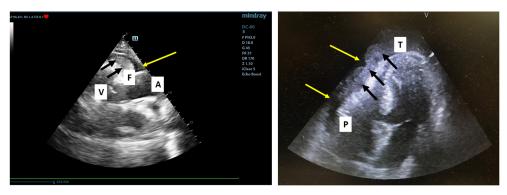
a.3. Left: a case with small quantity of pericardial fluid (transonic, yellow arrow) and intrapericardial fibrin (isoechoic homogenous structure, black arrows); F=fibrin, A=aorta, V=right ventricle (2D, parasternal long axis); Right: a case with cardiac tamponade with medium amount of pleural fluid (transonic structure, yellow arrows) and a big thrombus inside and RV collapse; T=thrombus, P=pericardium (hyperechoic structure) (2D, apical 4-chambers view)
